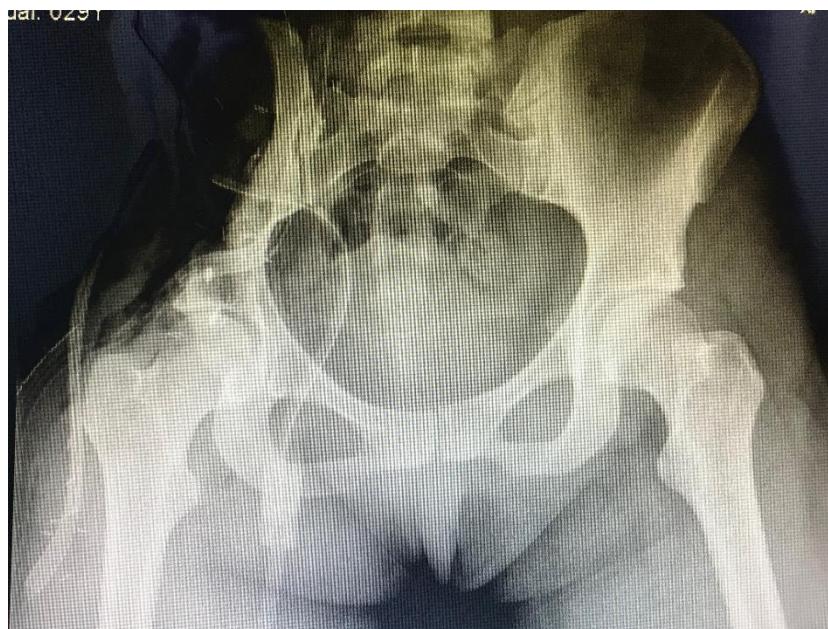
Post operatively X-Ray
